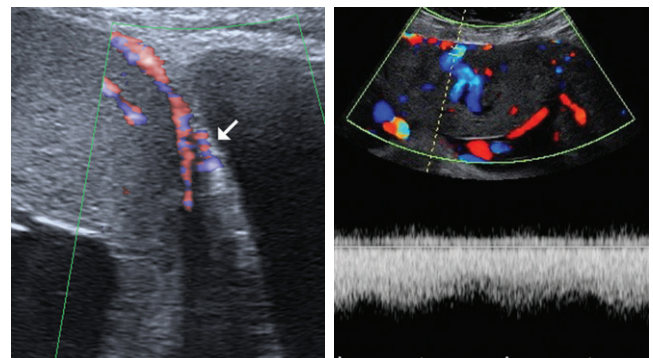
Bridging vessels on color Doppler imaging.
